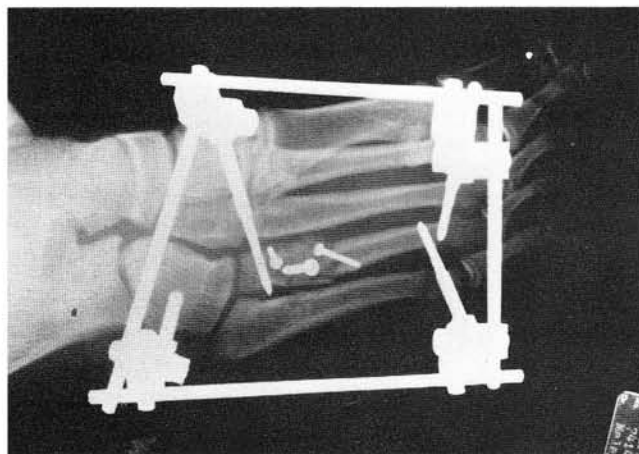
Oblique radiograph showing combination of external and internal fixation devices used in definitive reconstruction.
